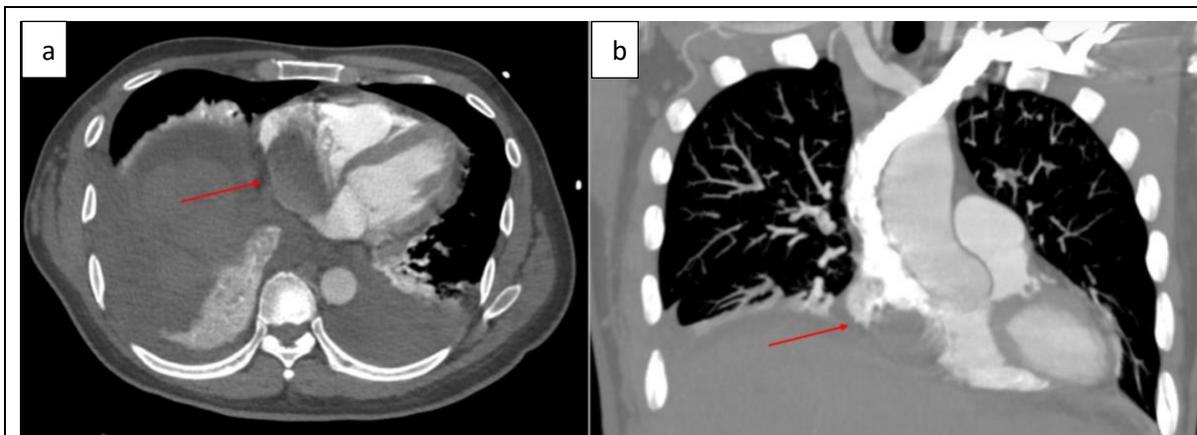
(a): CT demonstrating hepatic mass traveling along inferior vena cava into right atrium;
